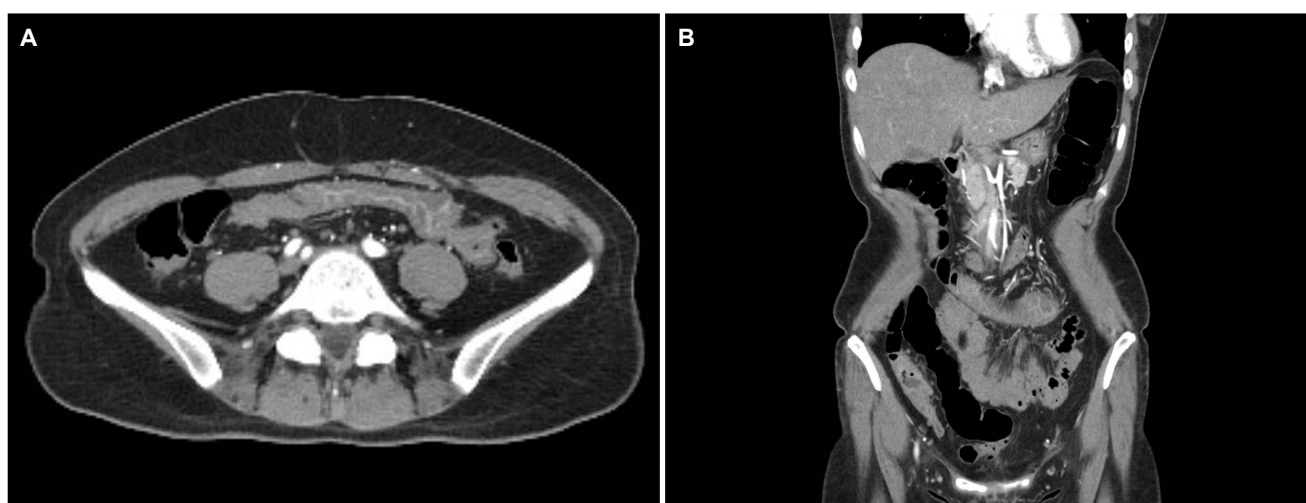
Abdominal computed tomography revealed submucosal edema of transverse colon (A) transverse section and (B) coronal section.
